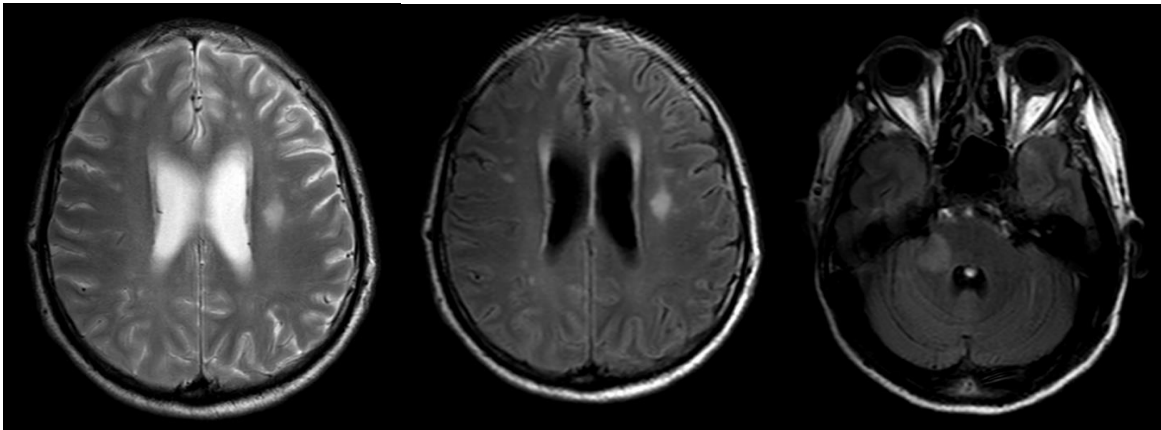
Magnetic resonance imaging of the head showing hyperintense lesions in T2 and FLAIR sequences, homogeneous, with defined borders, in the right cerebellar peduncle and left periventricular region. In addition, the presence of lesions of smaller size were observed in the subcortical matter of the frontal lobe, with a greater right predominance.
